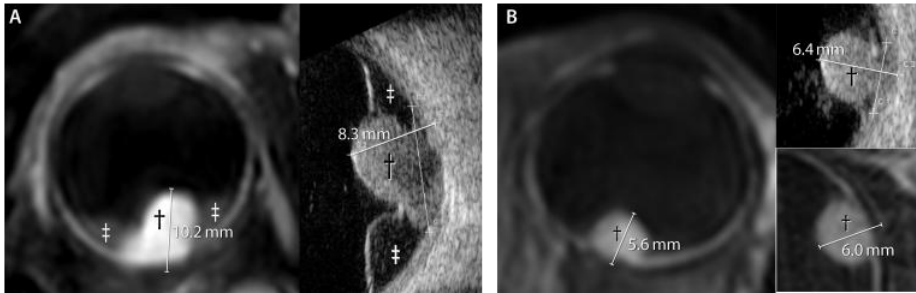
Examples of differences between US and MRI measurements. The tumor is marked with a dagger and the retinal detachment with a double dagger. (A) Example patient where the 2 mm difference prominence between both imaging modalities was attributed to an asymmetric tumor geometry. This shape caused a difference in axis along which the measurement was performed between the MRI (left) and US (right). This also resulted in a 3 mm difference in basal diameter measurement. (B) Papillary located UM, in which the sclera could not accurately be included in the measurement on the 3D contrast enhanced T1 MR-images (left). Retrospectively, for this specific patient a more accurate measurement could have been obtained on the MS T1 (lower right), showing a slightly more prominent tumor.
